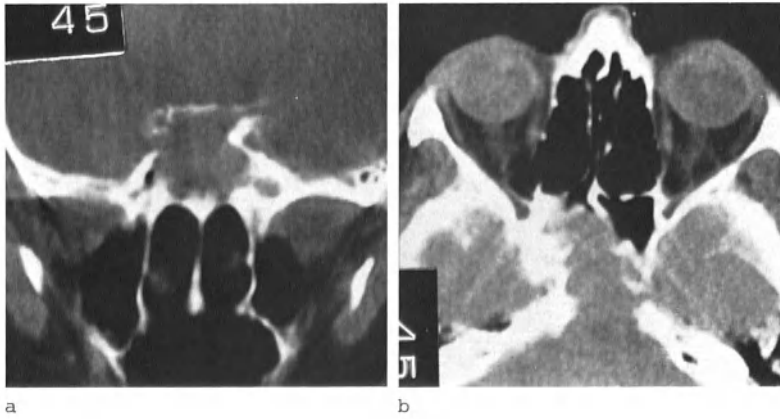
Pyocoele of the sphenoid sinus (a) Coronal CT (b) Transaxial CT. There is expansion and opacity of the sphenoid sinus with erosion of the roof and posterior wall
